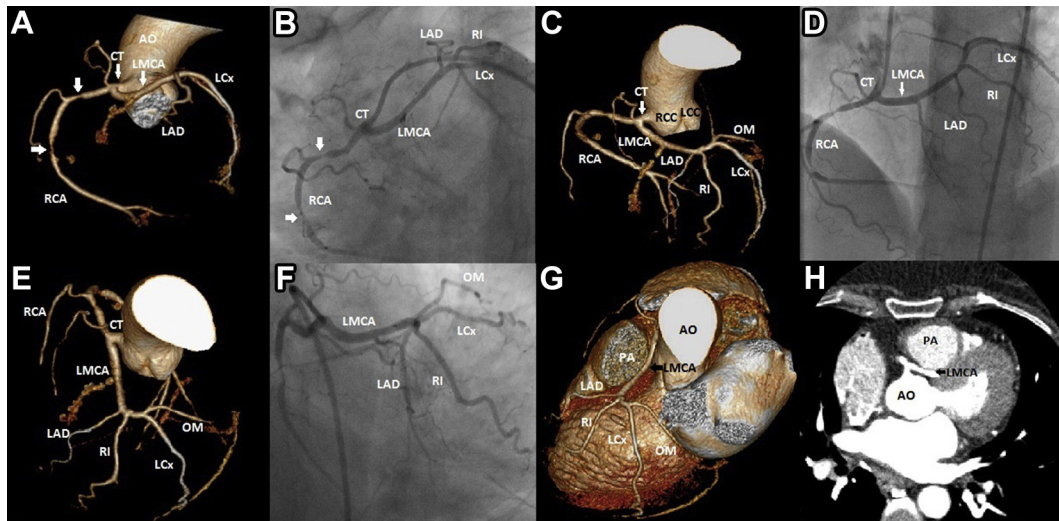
A, C, E (3-Dimensional volume rendered computed tomographic images of coronary tree) and B, D, F (coronary angiographic images of LAO caudal, LAO cranial, PA caudal views respectively) showed single coronary artery origin from right sinus of Valsalva as short common trunk (CT) bifurcate into right coronary artery (RCA) and long left main coronary artery (LMCA), LMCA further divided into type I small left anterior descending coronary artery (LAD), Ramus intermedius (RI) and left circumflex artery (LCx). RCA showed flow-limiting stenosis (90%) in proximal and mid portion (unpaired arrow head in Fig. A, B) G (volume rendered image of 3-Dimensional cardiac computed tomography (CCT)), H (short axis of CCT) demonstrated intra-arterial course of LMCA (black arrow head) between aorta (AO) and pulmonary artery (PA). RCC = right coronary cusp, LCC = left coronary cusp, OM = obtuse marginal branch.
